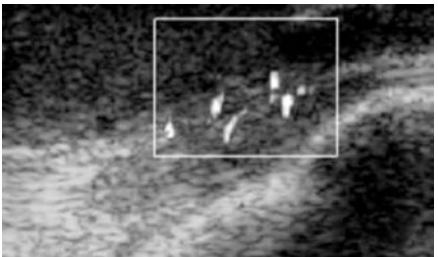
Power Doppler showing neovascularization in infrapatellar tendonosis.
